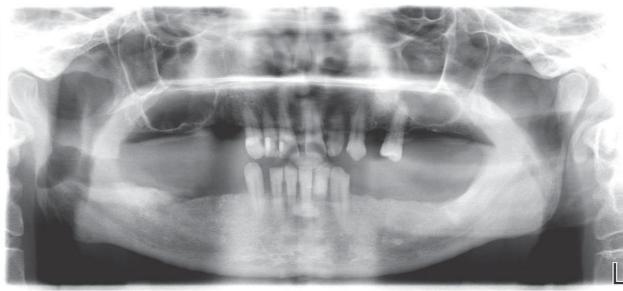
Orthopantomography after the surgical procedure.
